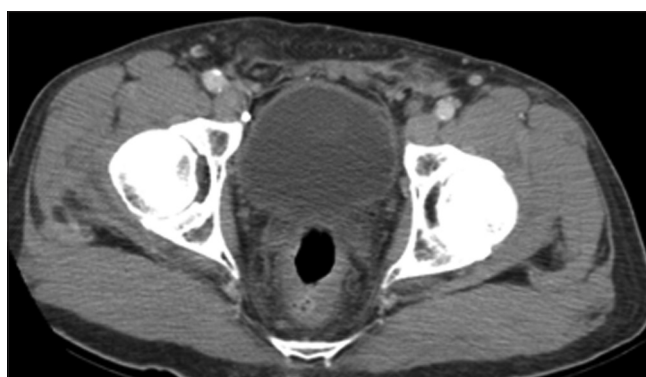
Contrast CT abdomen and pelvis shows complete resolution of the pelvic lymphoceles and complete re-expanding of the urinary bladder after successful laparoscopic marsupialization
